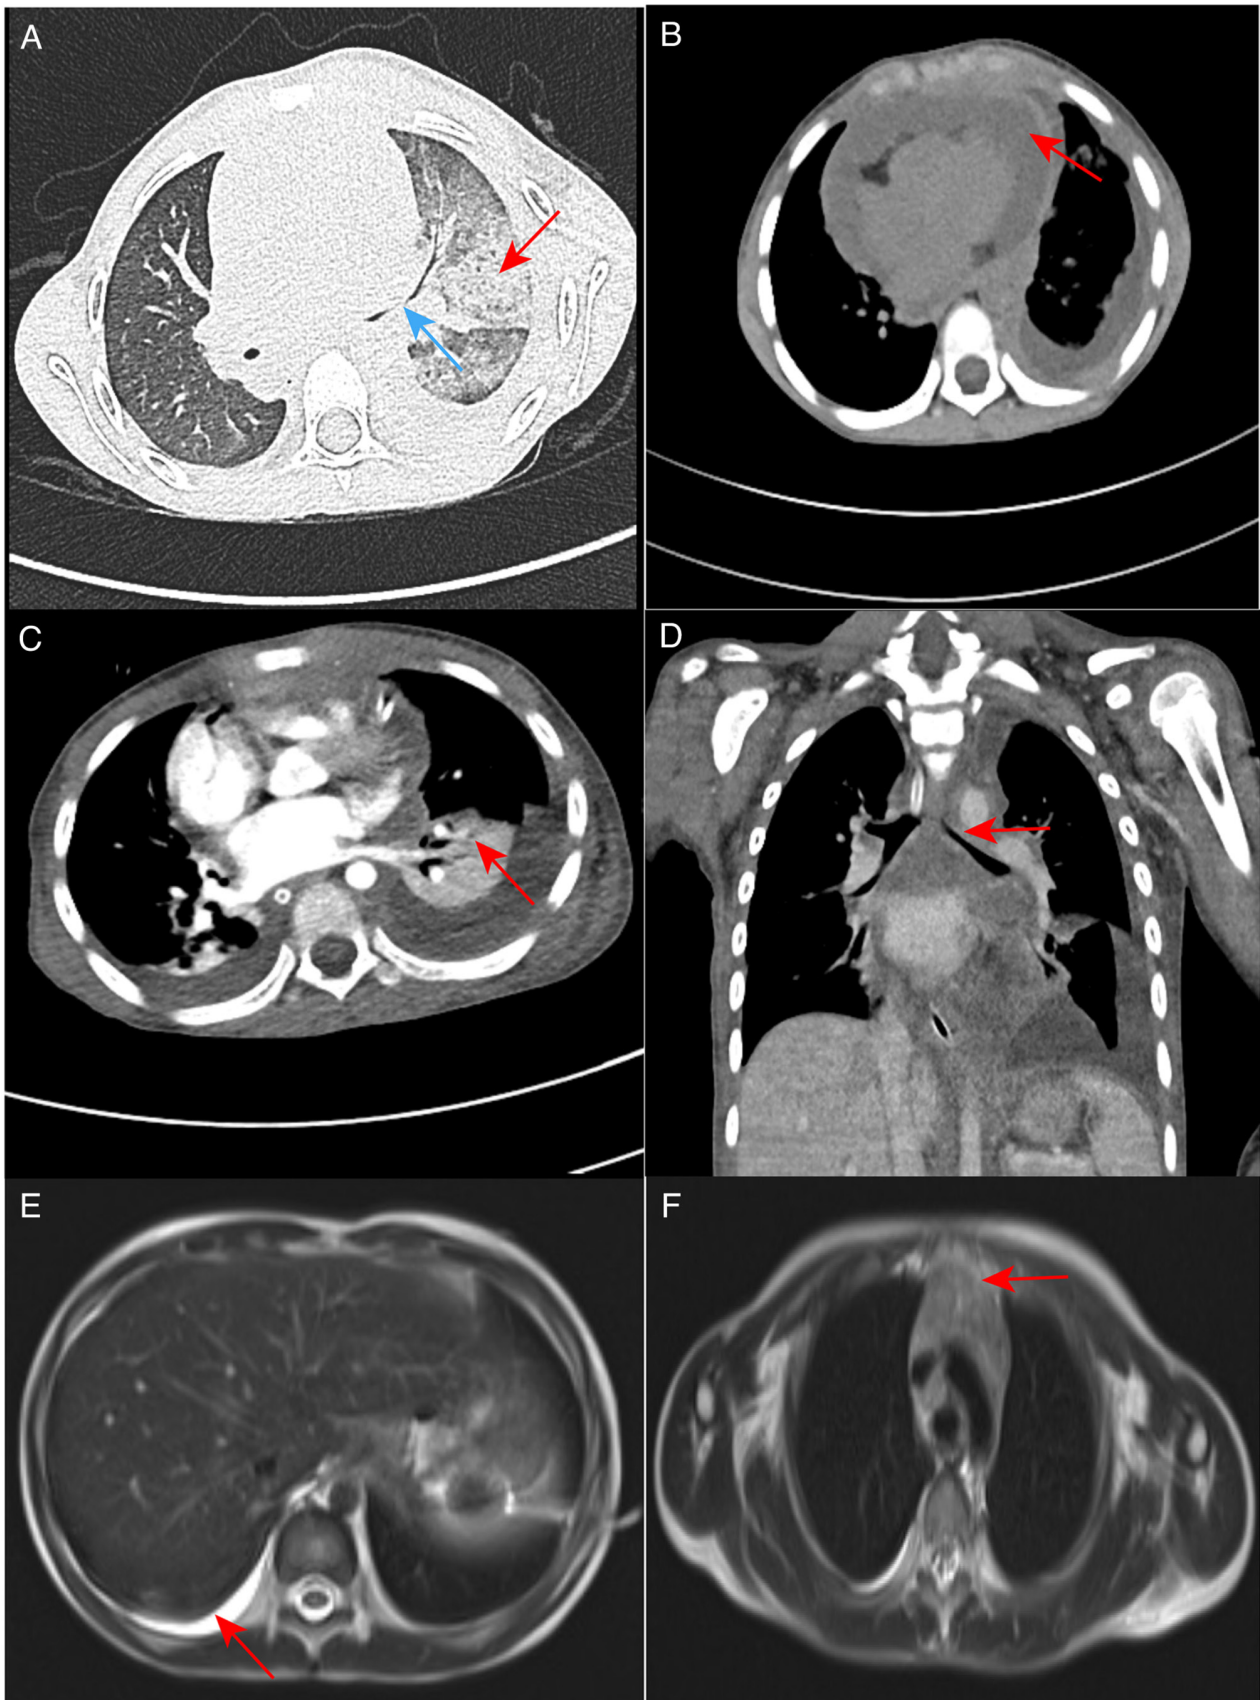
CT and MRI images of the patient. (A) High-resolution CT scan of the lungs in August 2022. Multiple areas of inflammation and exudation in both lungs are shown, with increased severity in the left lung (red arrow), left pleural effusion drainage, partial left lower lobe compression and expansion, and stenosis of the left main bronchus (blue arrow). (B) High-resolution CT scan of the lungs in August 2022; the mediastinal fat space appears blurred and indistinct, and the accumulation of a large amount of fluid is visible in the pericardium (red arrow). (C) Enhanced CT scans of the lungs in August 2022 show marked solidity in the left lung (red arrow) and (D) left main bronchial stenosis (red arrow). (E) In September 2022, an enhanced MRI scan of the mediastinum revealed significant pleural effusion on the right side (red arrow). (F) The thymus was enlarged (red arrow). CT, computed tomography; MRI, magnetic resonance imaging.
